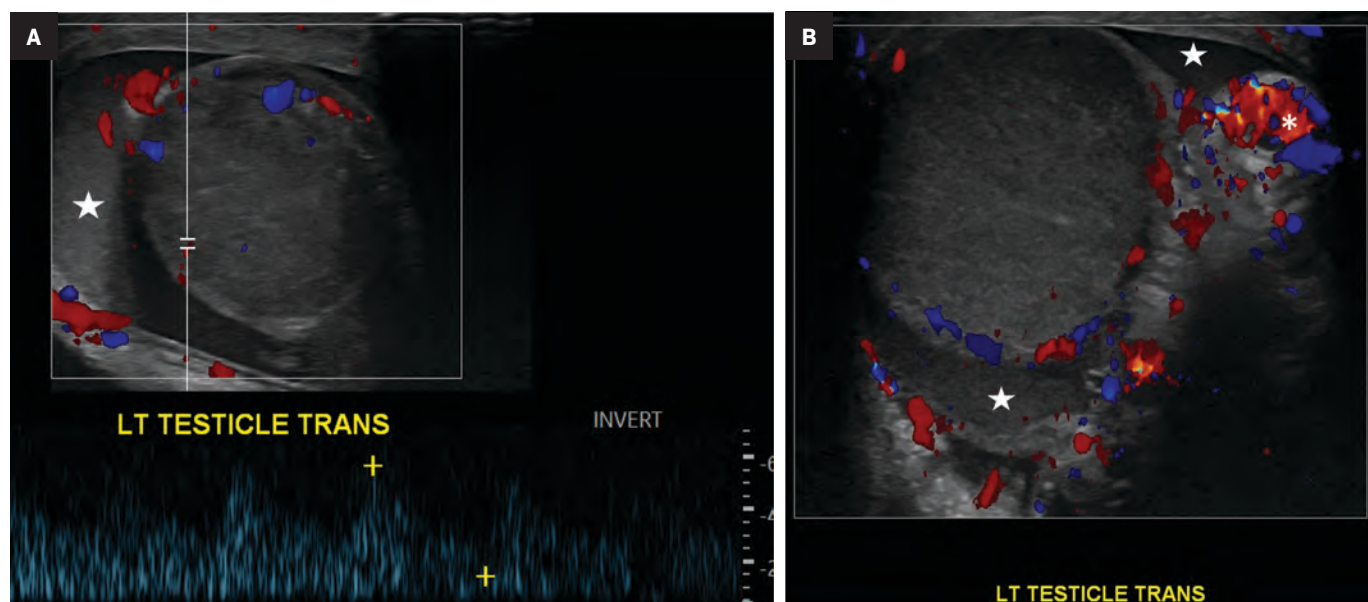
Teenager presenting with abdominal pain and vomiting, found to have incomplete left (270°) testicular torsion. Duplex and color Doppler ultrasound scans of the left testicle show Doppler flow only in the periphery of the testis (A, B). There is a positive whirlpool sign (B, *) Hematocele (star) is also shown (A, B). Echogenicity of the testicle was decreased compared to the right testicle, and the left testicle was black and necrotic at surgery.
